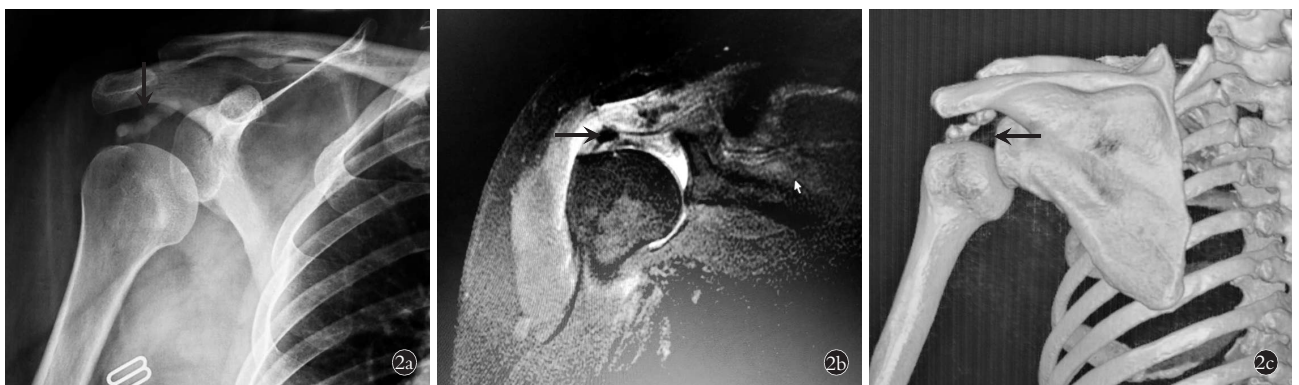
患者,女,36 岁,冈上肌腱钙化性肌腱炎 2a. 术前 X 线片示冈上肌腱钙化病灶,边界清晰,肩关节半脱位(黑箭头所示) 2b. 术前 MRI 示冈上肌腱钙化病灶,边界清晰,周围软组织水肿(黑箭头所示) 2c. 术前三维 CT 示冈上肌腱钙化病灶,边界清晰,病灶深入肩峰下间隙内侧(黑箭头所示)
